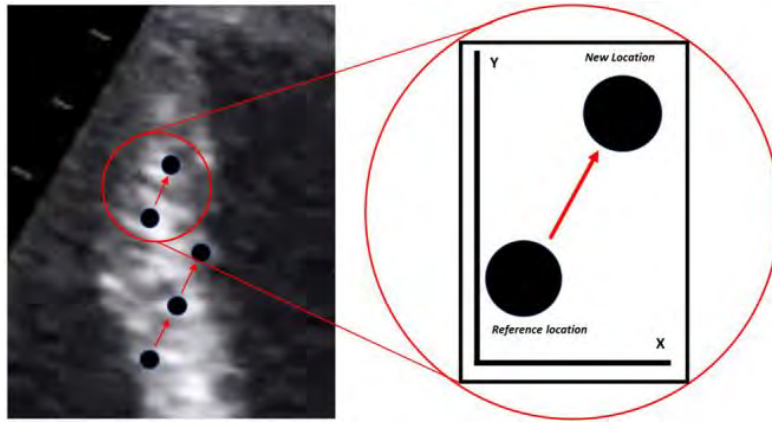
Theoretical concept of speckle tracking echocardiography.
